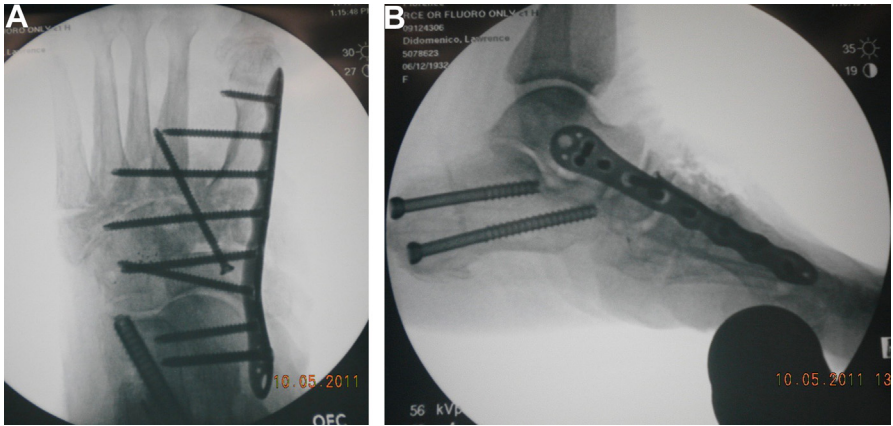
(A, B) An intraoperative lateral radiograph demonstrating anatomic alignment in preparation for arthrodesis. A percutaneous calcaneal osteotomy was performed in combination with the midfoot and Lisfranc arthrodesis.
